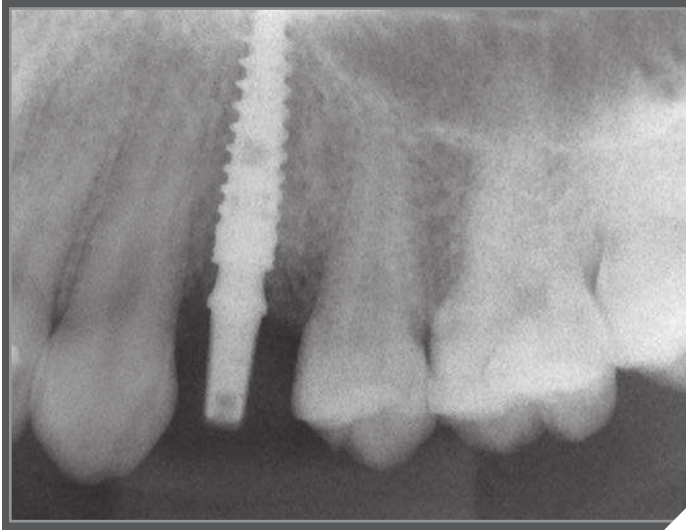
Periapical radiograph 30 days after surgery.
